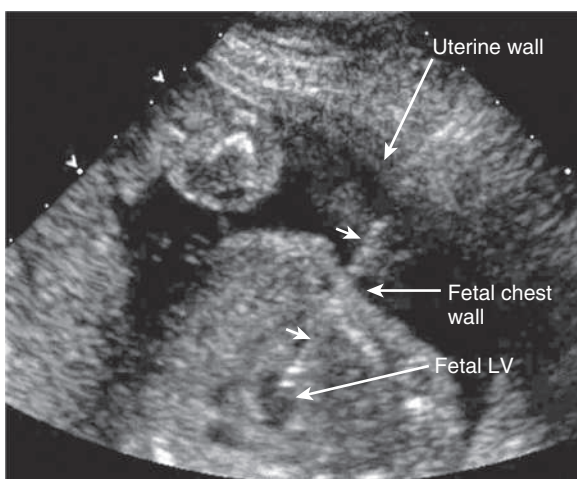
Fetal treatment of critical aortic stenosis to prevent development of hypoplastic left heart syndrome. Fetal ultrasound showing insertion of a needle (arrowheads) via the maternal abdominal wall, through the uterus and the fetal chest wall, and into the fetal left ventricle (LV). A balloon catheter is next inserted via the needle into the left ventricular chamber and across the stenotic aortic valve. The balloon is inflated to dilate the valve, and the catheter and needle are removed. (Courtesy Dr. Stanton Perry, Stanford University, Stanford, CA.)
